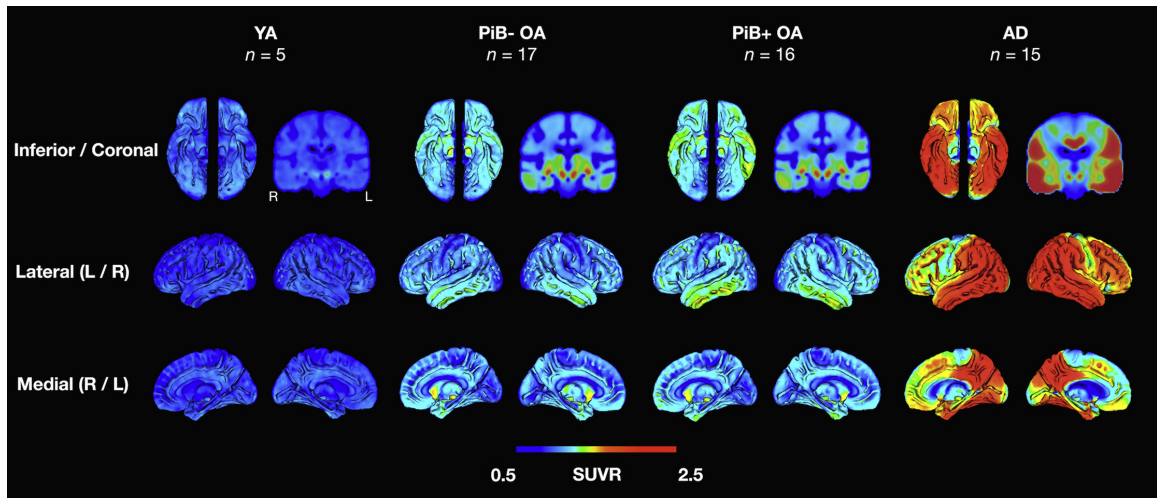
Stages of τ -protein progression from SUVR. Figure adapted from [4], showing the mean tau SUVR in a young adult population (YA), older adults (OA) with and without amyloid (determined by PiB PET), PiB- and PiB+, respectively, and subjects diagnosed with AD.
